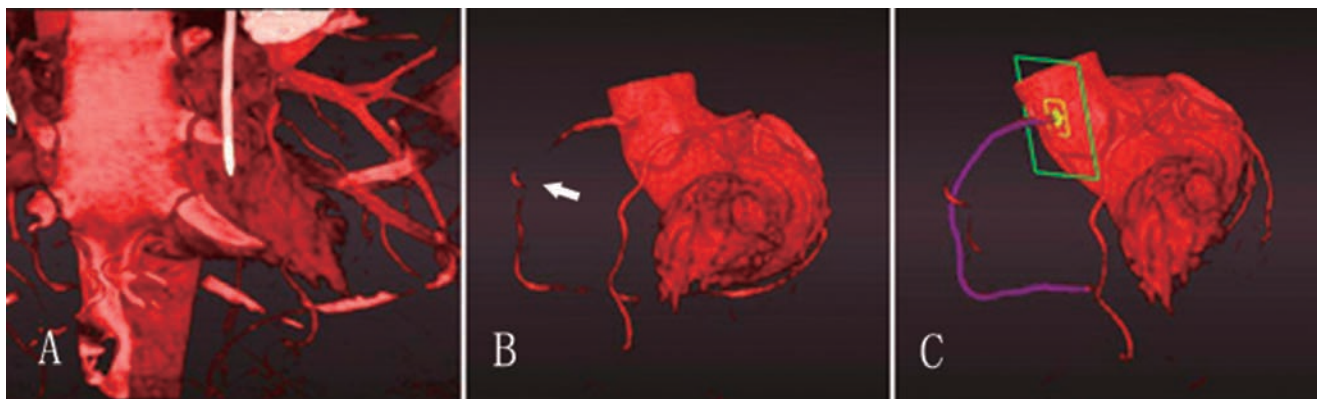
Reconstruction of the coronary arteries from computed tomography coronary angiography. (A) Preliminary image. (B) Coronary arteries exposed by manual editing of the computed tomography image; arrow shows a severe stenosis in the mid-right coronary artery. (C) Reconstruction of the right coronary artery.
